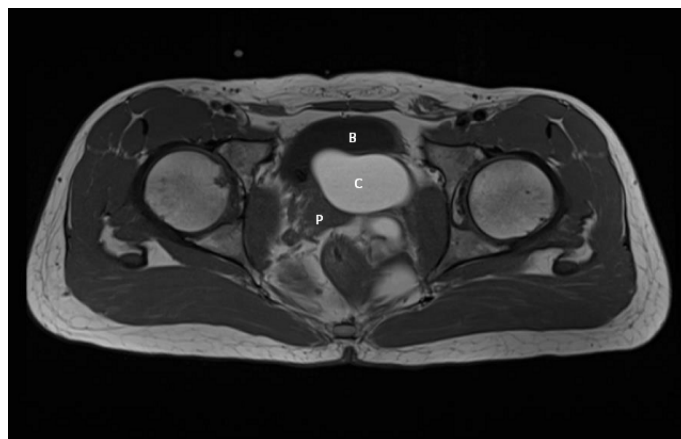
Axial T1-weighted images of MRI. The cystic lesion (C) at the level of the left seminal vesicle compresses on the bladder (B) from the posterior and on the prostate (P) from the lateral
